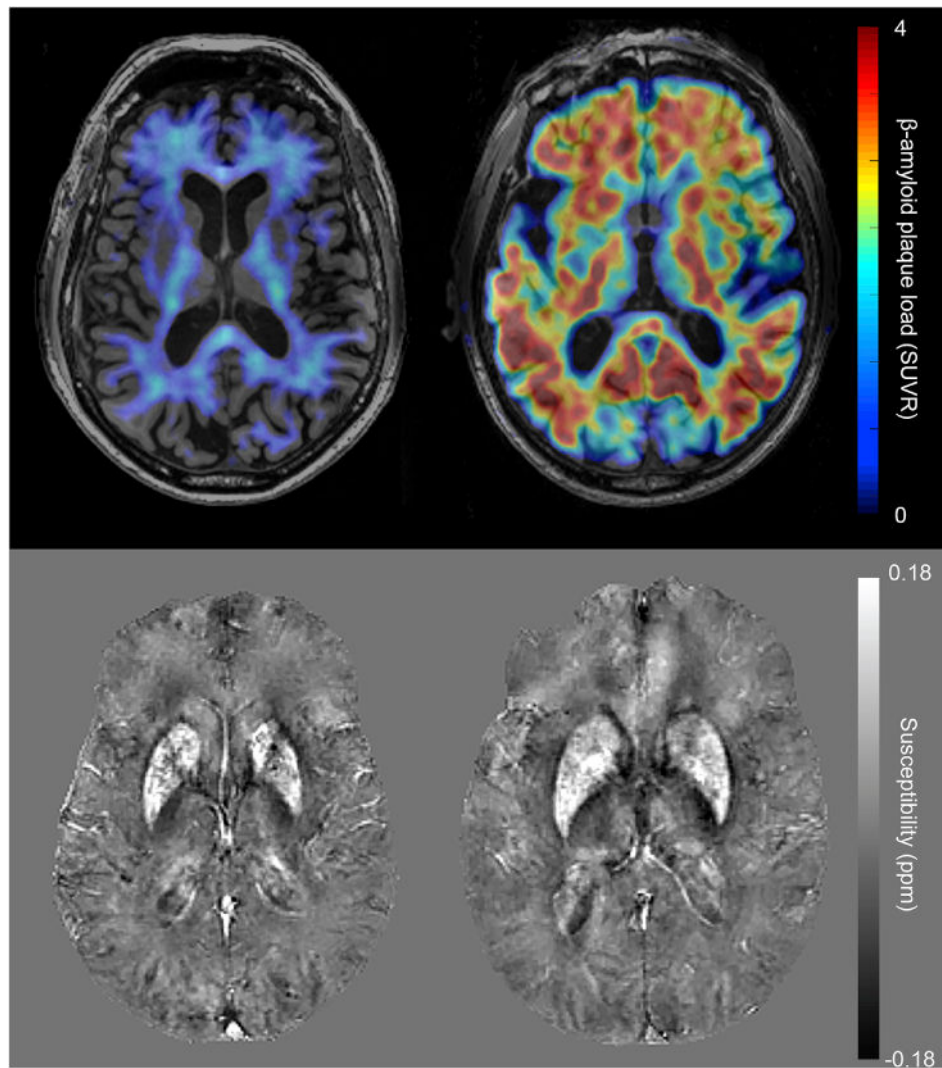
Example images of A β - (left) and A β + (right) participants. The top row shows 18F-Flutemetamol SUVR images, in which the A β - participant exhibits mostly non-specific white matter uptake while the A β + participant has high β -amyloid plaque load throughout all gray matter regions. The bottom row shows the identical slice in the QSM maps of these participants.
